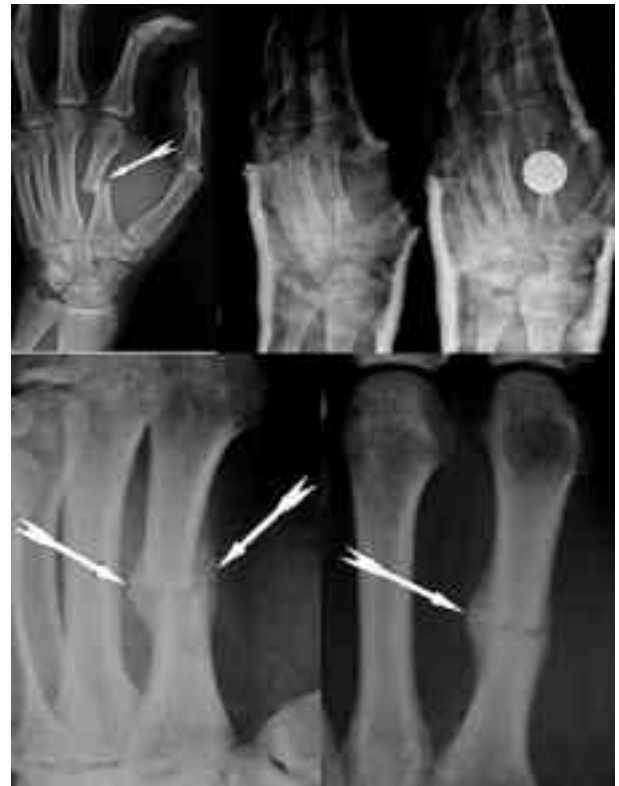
Dislocated fracture of the medial 1/3 second metacarpal of the left hand. X-ray of the fracture after reduction and placement in a plaster cast with and without a magnet and at the removal of the cast with presence of abundant bone callus
